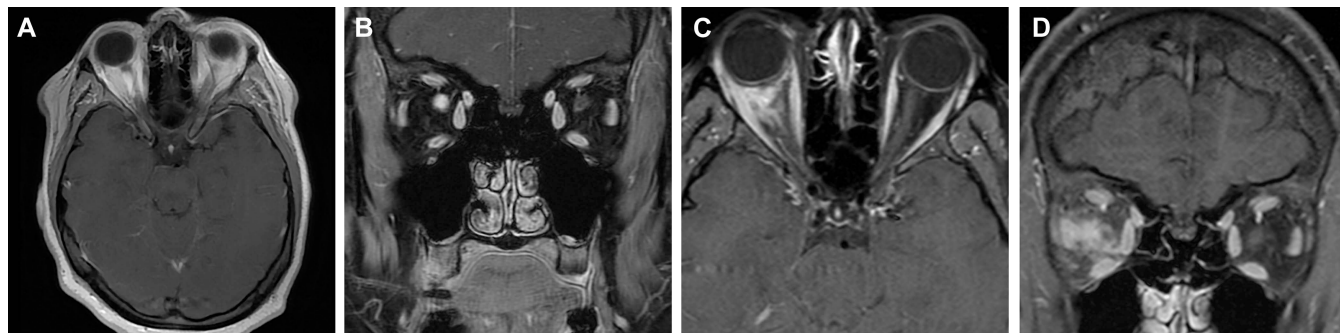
Preoperative T1-weighted axial A and coronal B MRI of the brain with contrast enhancement demonstrating a right optic nerve lesion suggestive of an optic nerve glioma. T1-weighted axial C and coronal D MRI of the brain with contrast enhancement demonstrating growth of the right optic nerve lesion.
